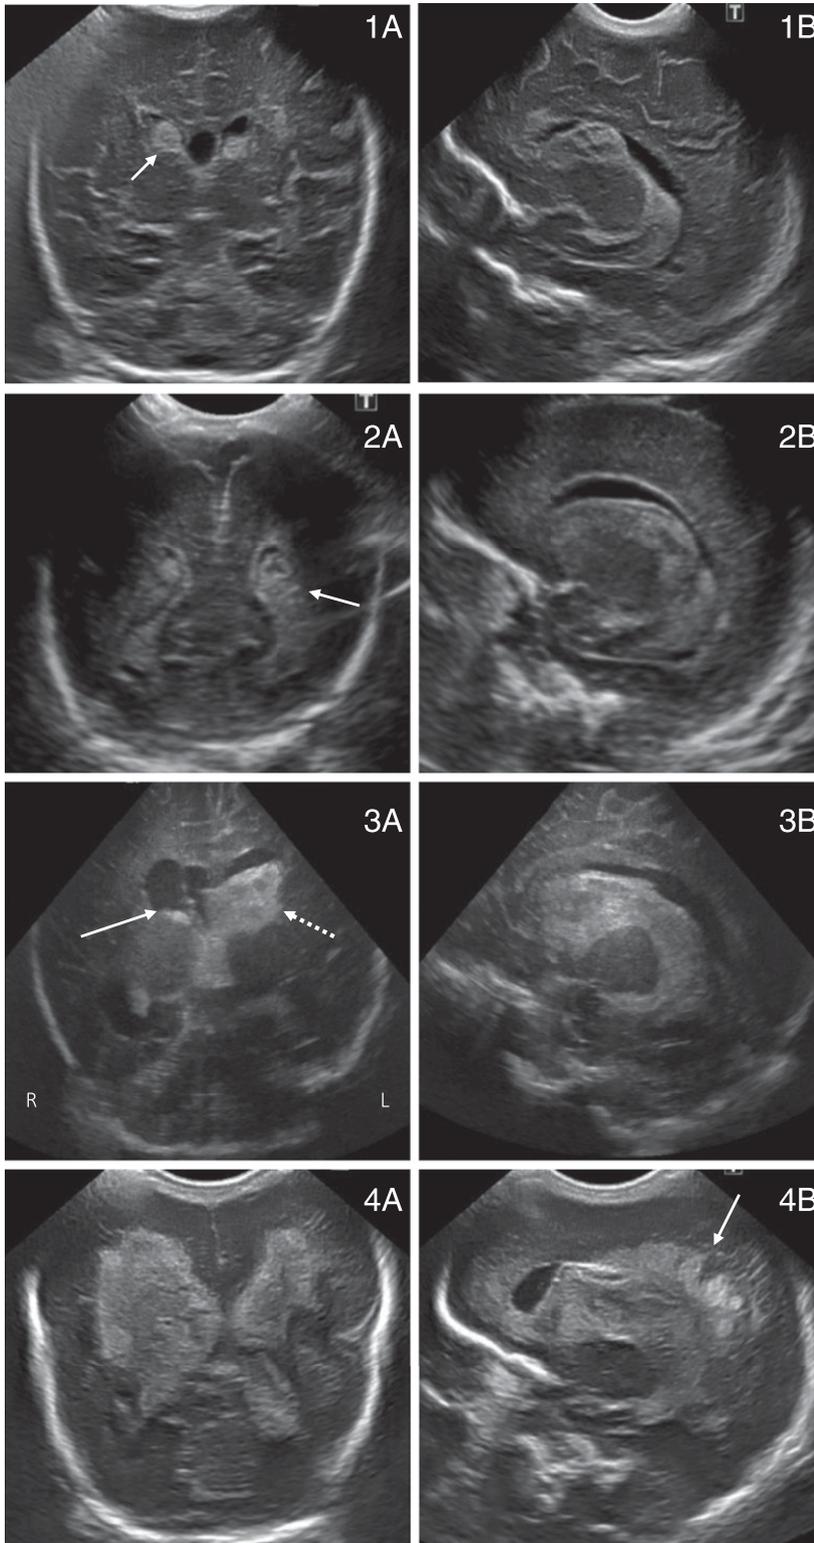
Cranial ultrasound images based on Papile grading system. 1A. Coronal image of bilateral grade 1 intraventricular hemorrhage with a solid arrow pointing at a germinal matrix hemorrhage. 1B. Sagittal image of grade 1 intraventricular hemorrhage. 2A. Coronal image of bilateral grade 2 intraventricular hemorrhage with a solid arrow pointing at a grade 2 intraventricular hemorrhage with blood in the ventricle and no ventricular dilation. 2B. Sagittal image of grade 2 intraventricular hemorrhage. 3A. Coronal image of left-sided grade 3 intraventricular hemorrhage and right-sided grade 2 intraventricular hemorrhage. Dashed arrow is pointing at a dilated ventricle filled with blood. Solid arrow is pointing at blood in the ventricle without ventricular dilation. 3B. Sagittal image of grade 3 intraventricular hemorrhage. 4A. Coronal image of bilateral grade 4 intraventricular hemorrhage with bleeding into the ventricles causing dilation and parenchymal hemorrhage. 4B. Sagittal image of grade 4 intraventricular hemorrhage with a solid arrow pointing at hemorrhage in the parenchyma.
